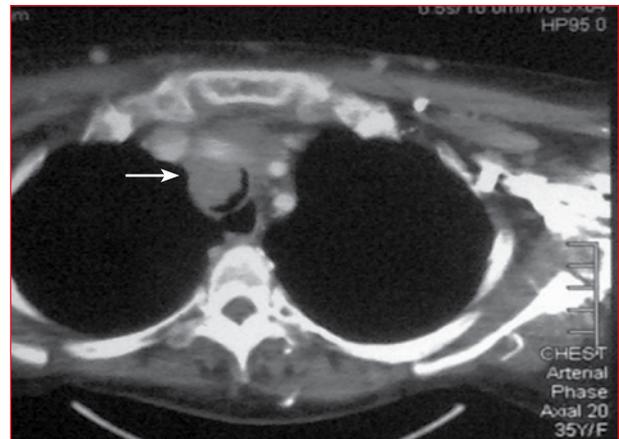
Computed tomography of the chest demonstrating superior mediastinal mass (arrow)
